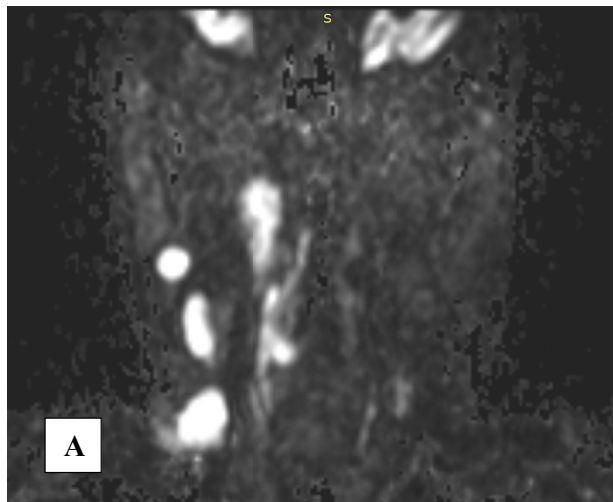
DWI image showing shapes of lymph nodes:
